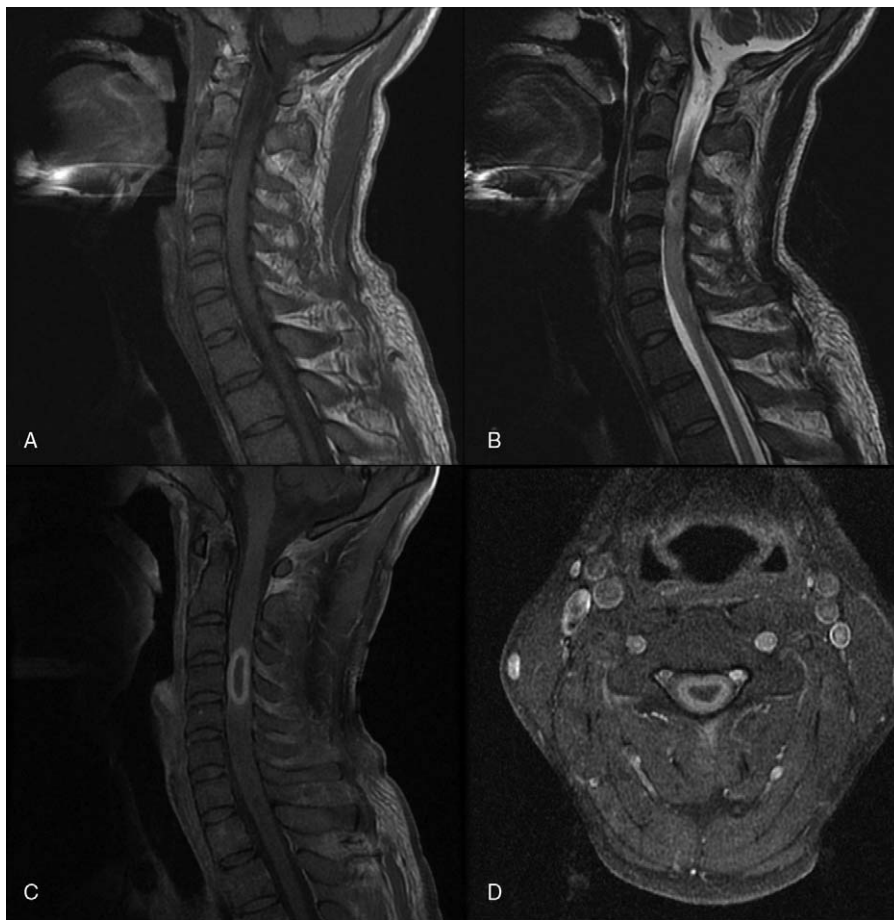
Magnetic resonance imaging (MRI) of the patient: (A) T1WI shows spinal cord swelling. (B) T2WI shows hyperintense lesion at C3 and C4 levels. (C) Contrast-enhanced T1WI shows typical target sign. (D) Axial view of the contrast-enhanced T1WI shows intramedullary lesion.
